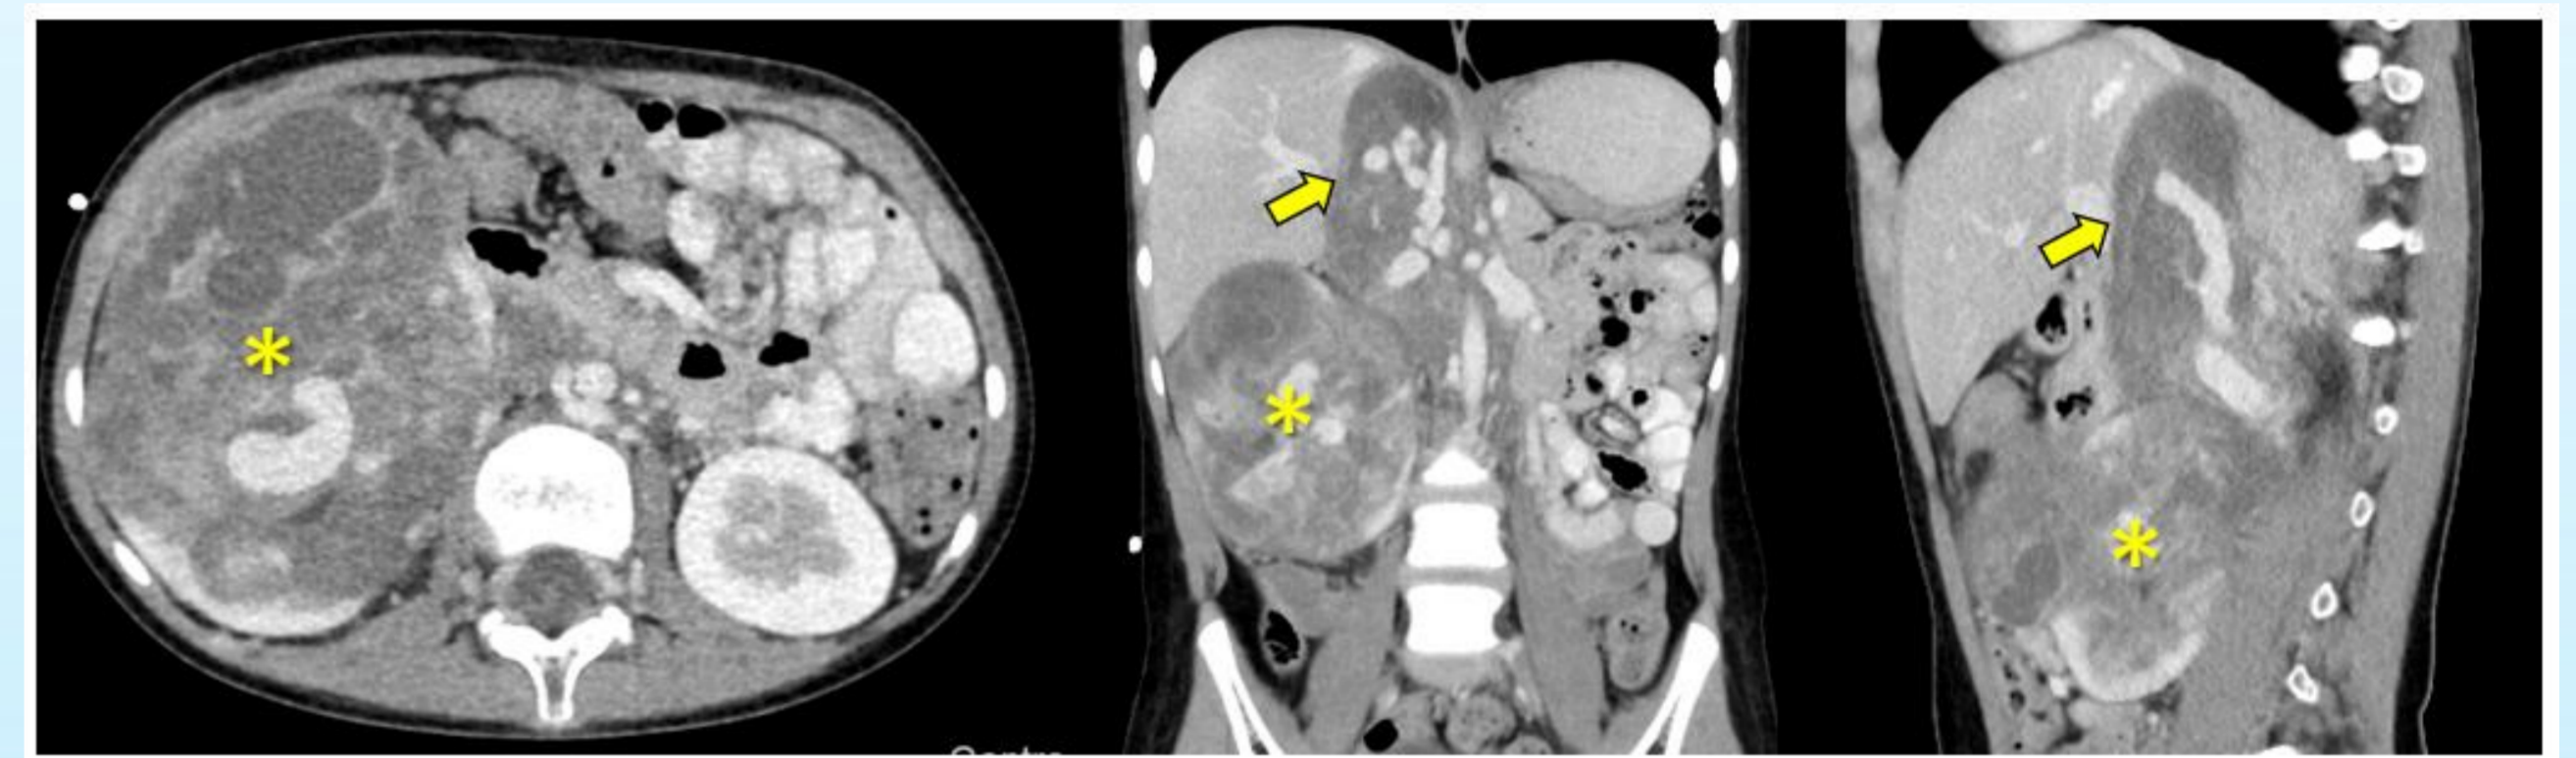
CT images after neoadjuvant chemotherapy showed no significant changes of primary tumour size (asterisk) and the non-resolution of the intracaval tumour thrombus (arrow)
